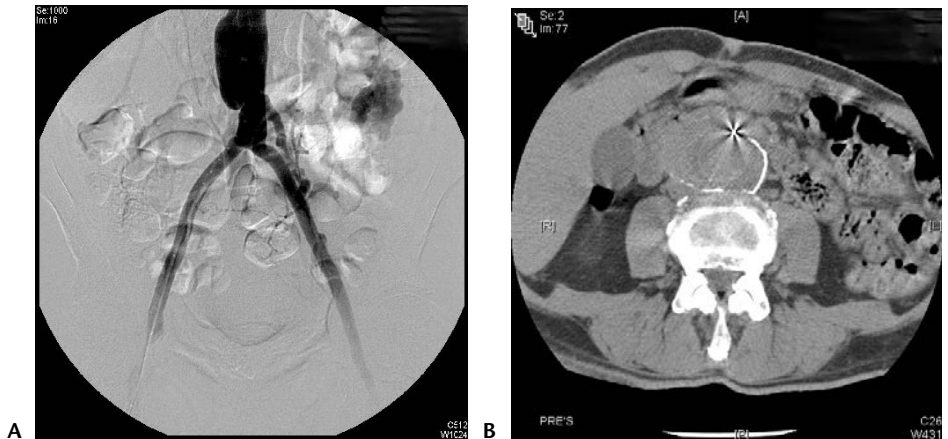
A: Proximal anastomotic aneurysm. B: CT of proximal anastomotic aneurysm.
